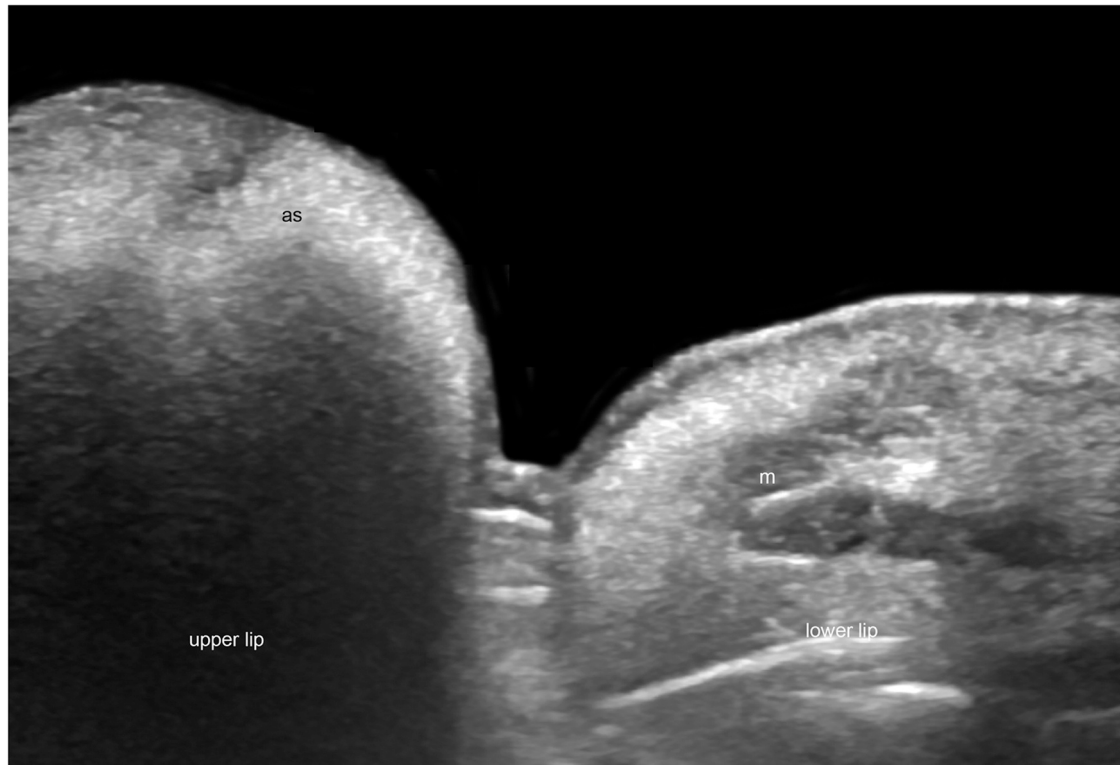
Ultrasound (longitudinal view; grayscale) of the lesion shown in Figure 1 demonstrates silicone oil in the dermis, subcutis, and the orbicularis muscle of the upper lip. Notice the "snowstorm" artifact generated by the silicone oil. The lower lip is unremarkable. Abbreviations: as, silicone oil; m, orbicularis oris muscle.
